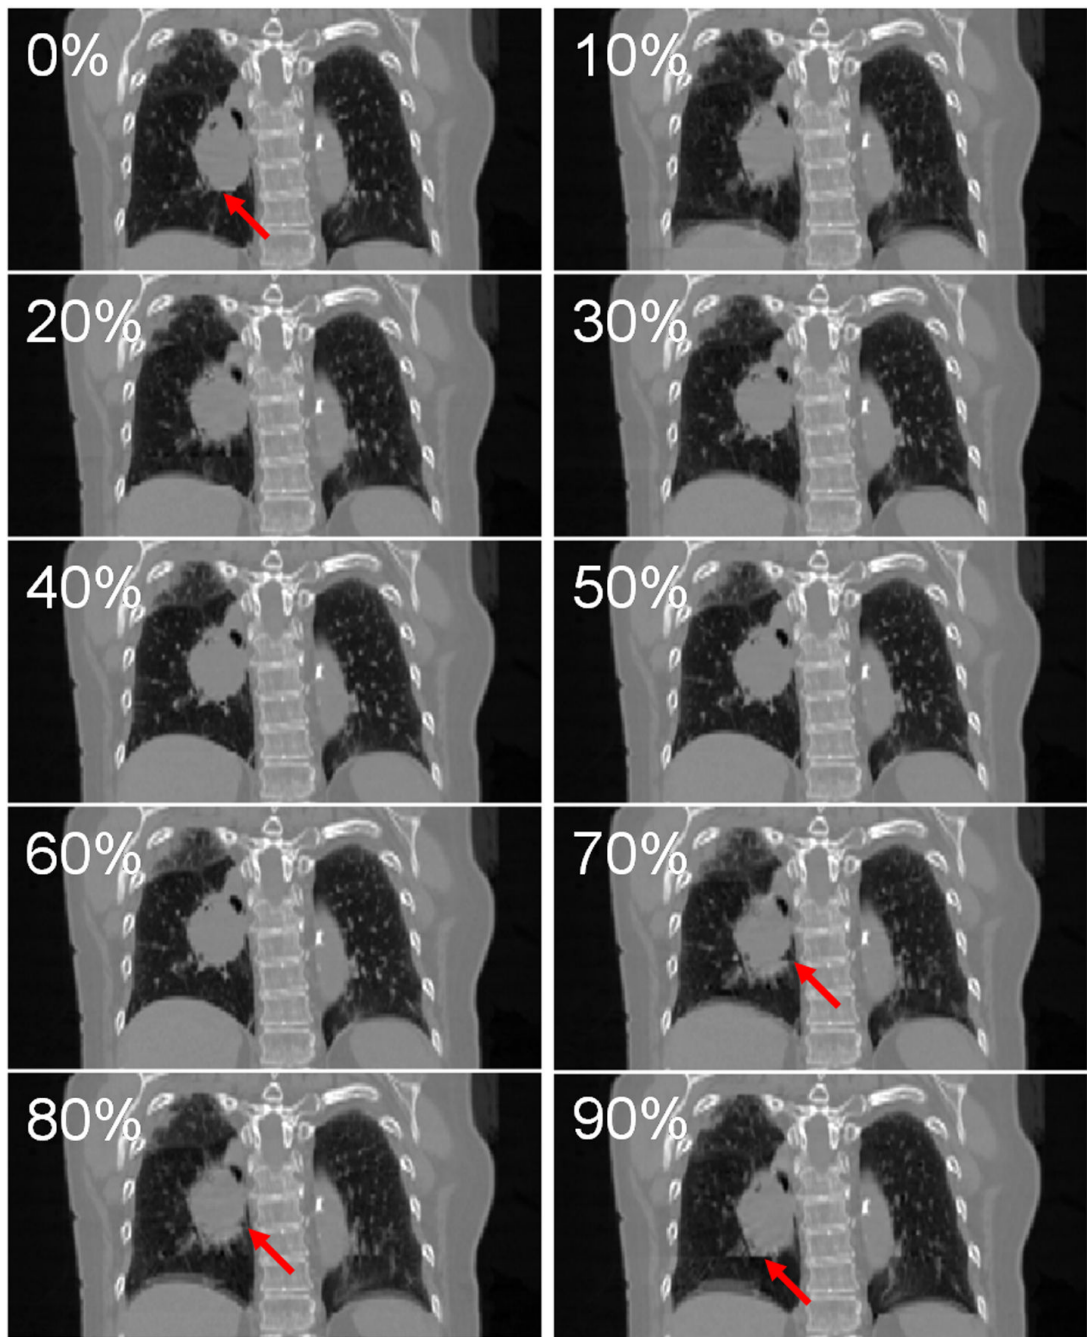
Example 4D-CT images of a patient with lung tumor artifacts: 0%–90% respiratory phase from top to bottom. Images at 0%, 70%, 80% and 90% phases had artifacts as indicated by arrows in respective images. Note that blurring and incomplete structure artifacts can also be observed in the right and left diaphragms, respectively.
